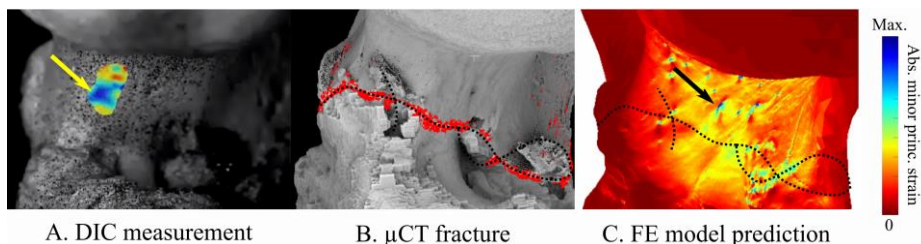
A) Strains measured using DIC. B) Registered μ CT segmentations showing the fractured region. C) Strains predicted by the linear FE model based on the μ CT images. The black dotted lines represent the experimentally fractured region. The arrows point at the high strains measured and predicted in and around the same foramen.
